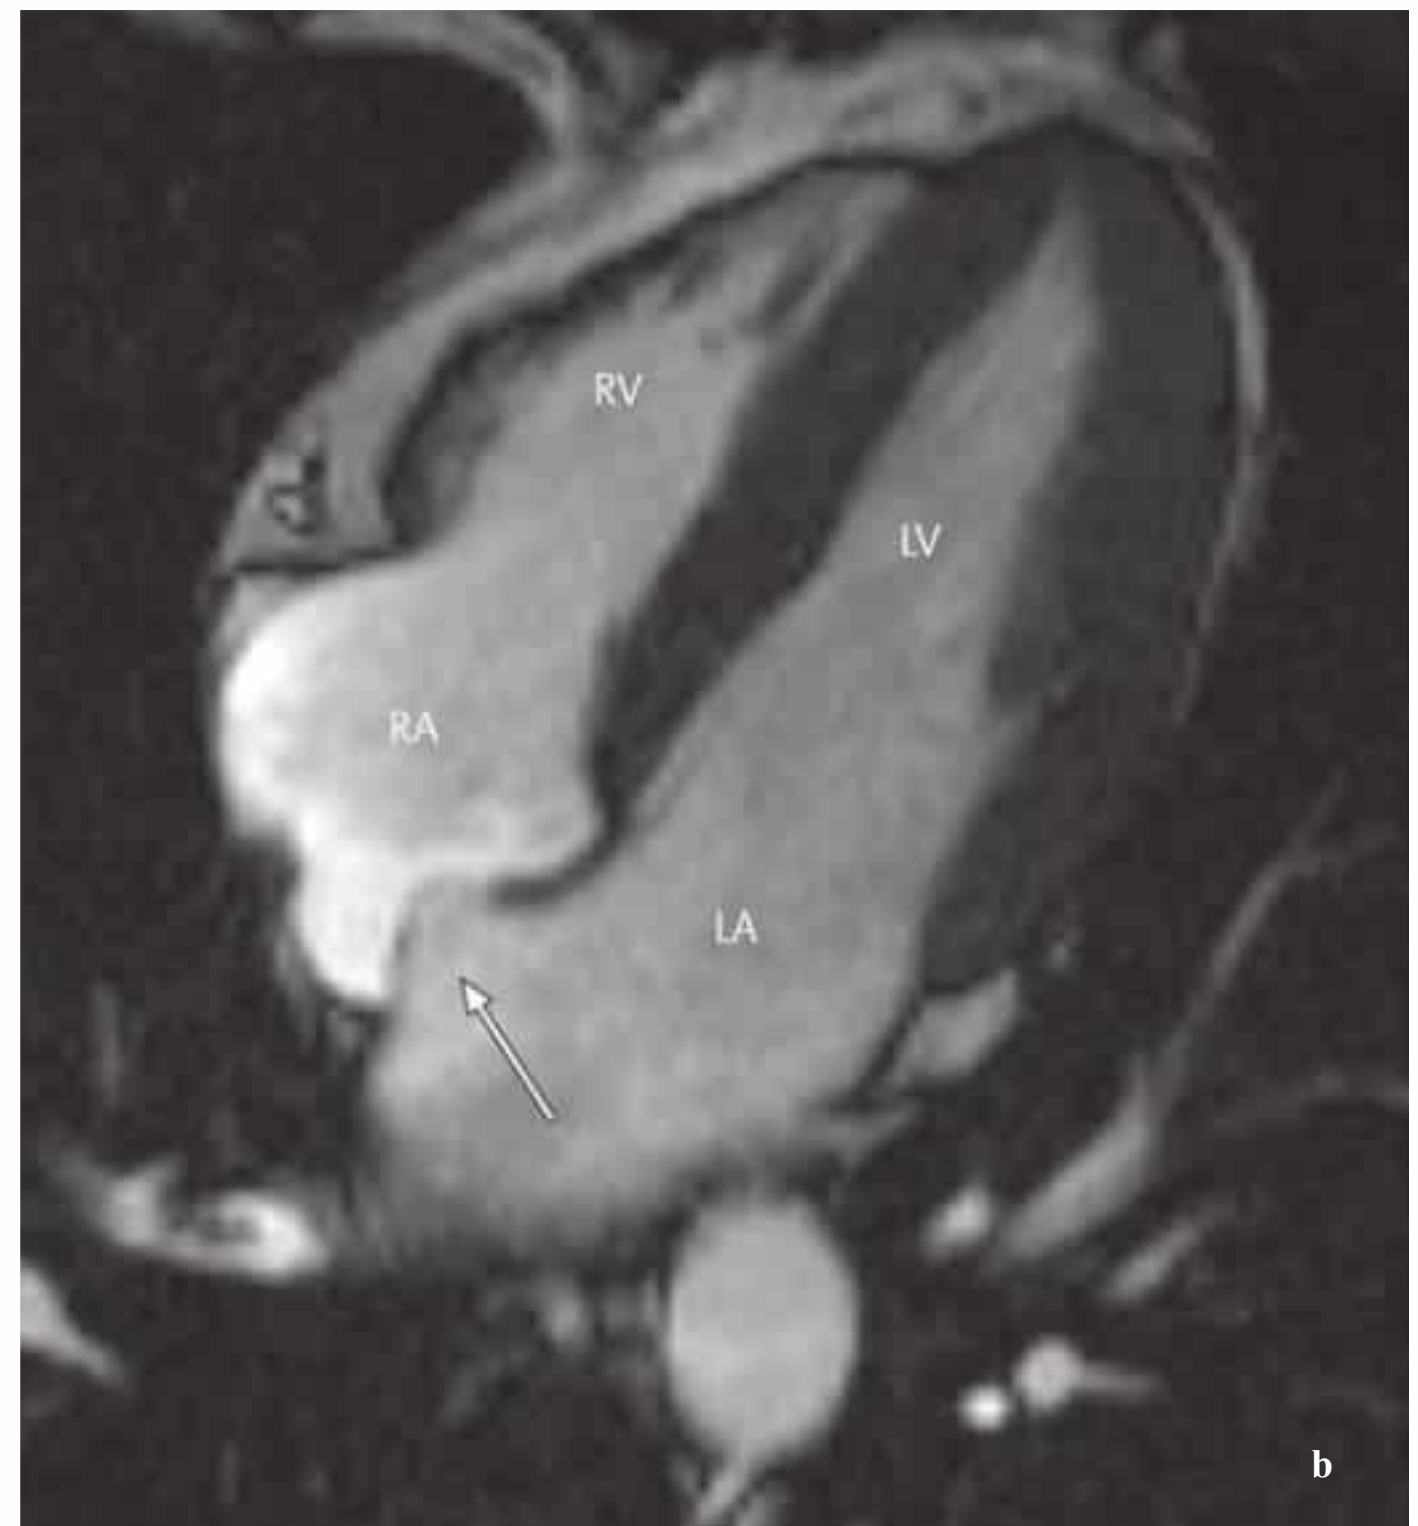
a, b Detection of a hypermobile atrial septal aneurysm (arrow). Cine MRI shows the aneurysm bulging into the left atrium during systole (a) and into the right atrium in early diastole (b).
